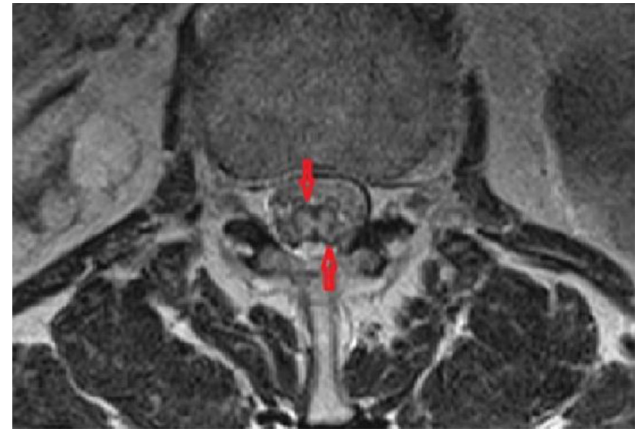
Gray matter butterfly pattern of cord infarction (red arrows) in axial T2-weighted magnetic resonance imaging.
